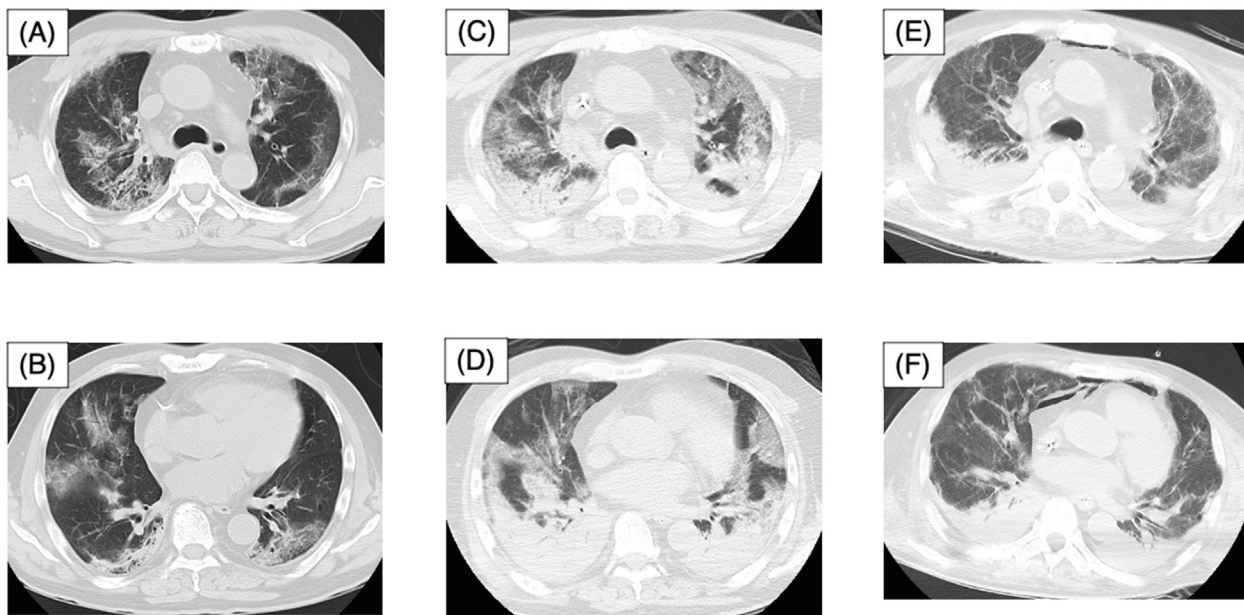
Serial chest CT images of the patient. (A) Hospital day 8, Upper lobes (B) Hospital day 8, Lower lobes (C) Hospital day 12, Upper lobes (D) Hospital day 12, Lower lobes (E) Hospital day 56, Upper lobes and (F) Hospital day 56, Lower lobes. (A, B) Bilateral upper and lower areas of ground glass opacities and consolidations at the subpleural and peribronchial regions. (C, D) Increased bilateral ground glass opacities and dorsal consolidations with air bronchogram. (E, F) Improvement in the bilateral ground glass opacities. Slight mediastinal emphysema can be seen.
